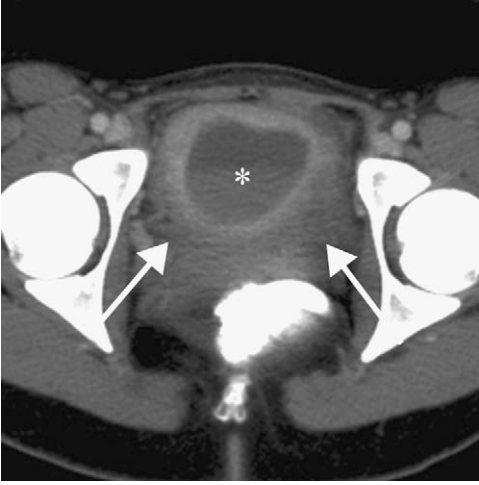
Endometritis from pelvic inflammatory disease. Axial-enhanced computed tomography shows a fluid/debris level within the endometrial cavity (*). Note the ill-defined borders of the uterus and the free pelvic fluid (small arrows).
